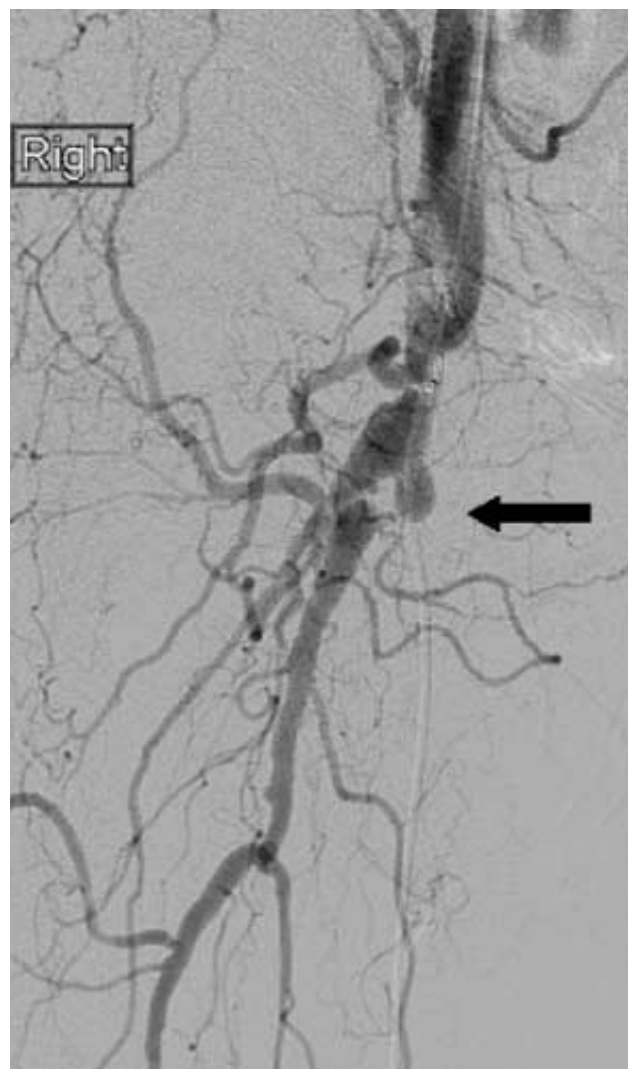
Arterial thrombolysis. Patient presented with grade IIa ischemia, and duplex ultrasonography showed evidence of an occluded femoropopliteal reverse saphenous vein bypass graft. Angiogram taken from the ipsilateral external iliac artery demonstrating a patent but diseased CFA and a patent PF. The SFA is occluded. The stump of the occluded arterial bypass graft is visible (arrow).
